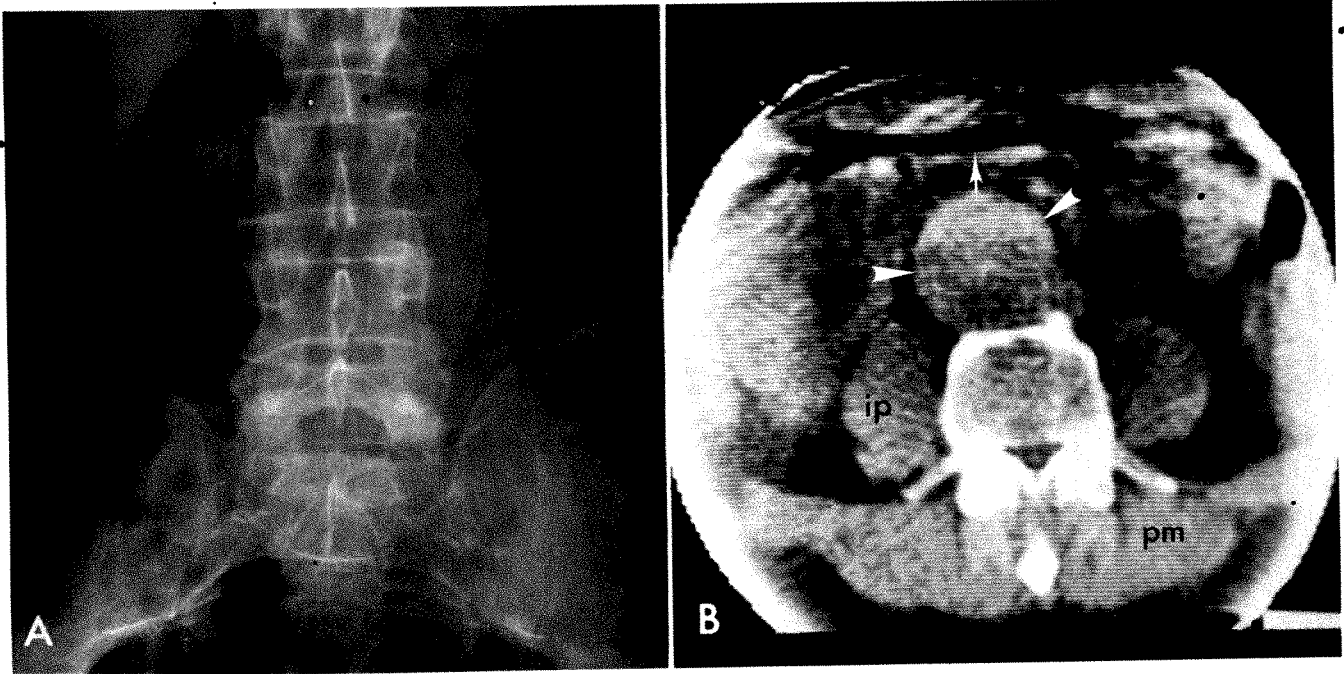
A, Abdominal aneurysm delineated laterally by its calcific wall; medial wall not recognized. B, CT scan showing more accurate depiction of transverse extent of aneurysm (arrowheads). Note air-fluid level in stomach (arrow), prominent iliopsoas (ip), and posterior paravertebral muscles (pm) in this mesomorphic individual.
